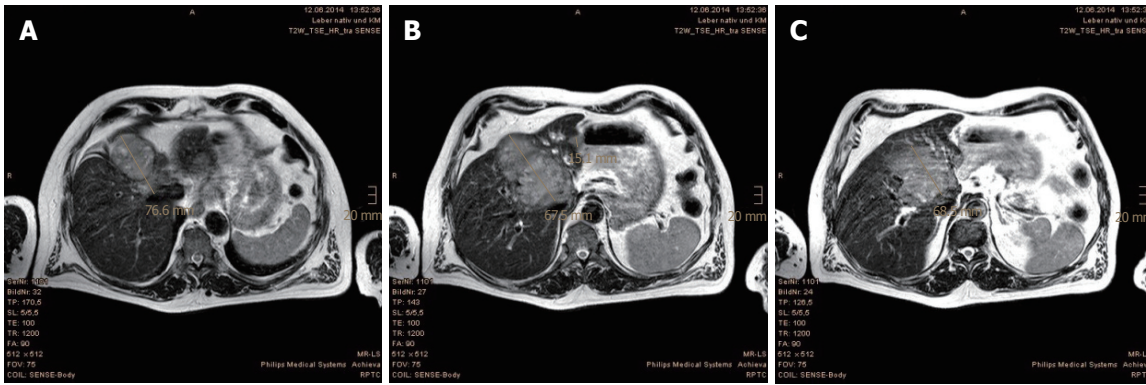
Tumor regression evidenced in the first follow-up magnetic resonance imaging scan at 3 mo after proton beam therapy. A-C: Size reductions of the main tumor and the liver metastases are shown, measured in three levels of axial plane.
